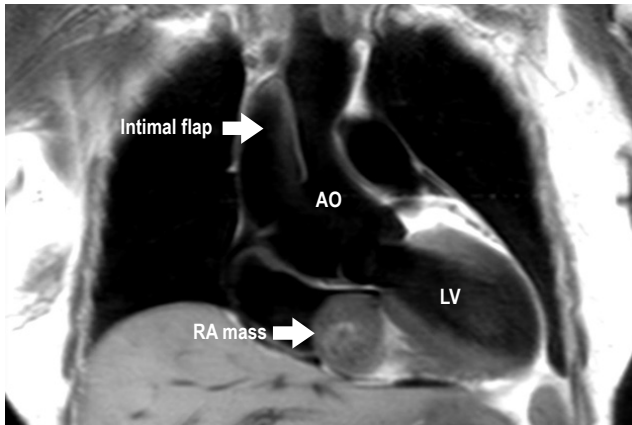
T1-weighted dark blood image, the RA mass showed isosignal intensity relative to myocardium on T1-weighted spin echo image. Aneurysmal change and dissection (intimal flap) of the ascending thoracic aorta.
